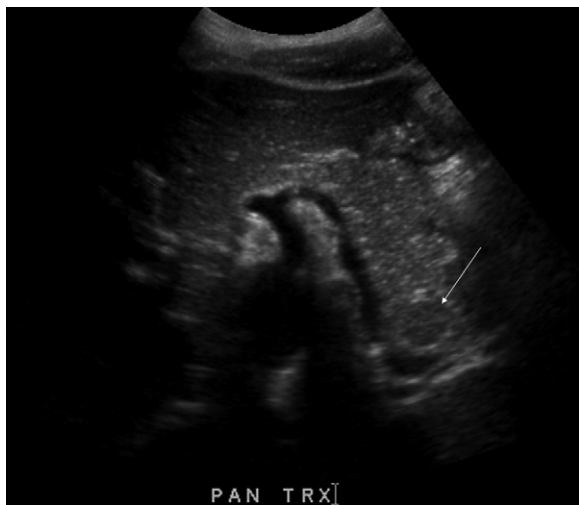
Transverse ultrasound image showing a homogeneous, well-defined, round hypoechoic mass in the pancreatic tail.
